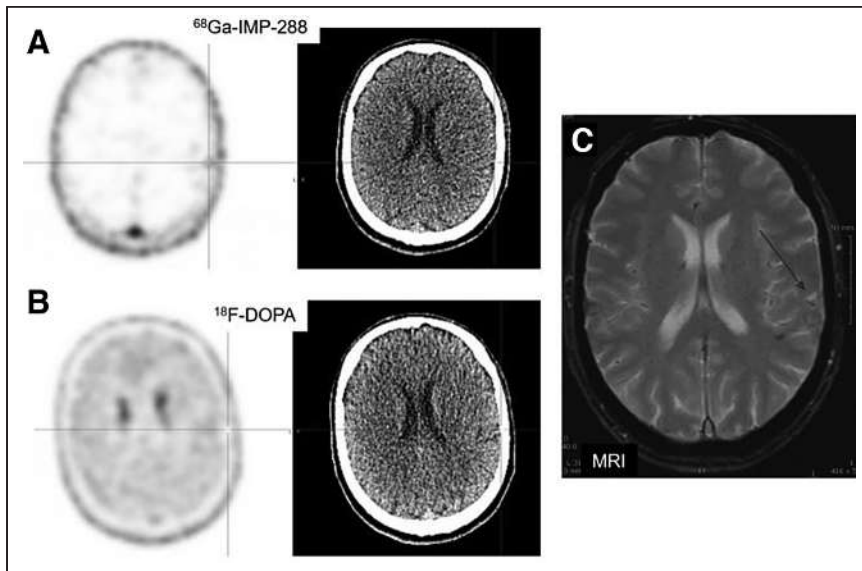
(A) Immuno-PET images with anti-CEA BsmAb and ^{68}Ga -IMP288 showing temporoparietal uptake in brain. CT of the PET/CT was negative. (B) PET/CT with ^{18}F -DOPA PET/CT was negative. (C) Brain MRI (guided by immuno-PET) confirmed pathologic temporoparietal lesion (arrow).
